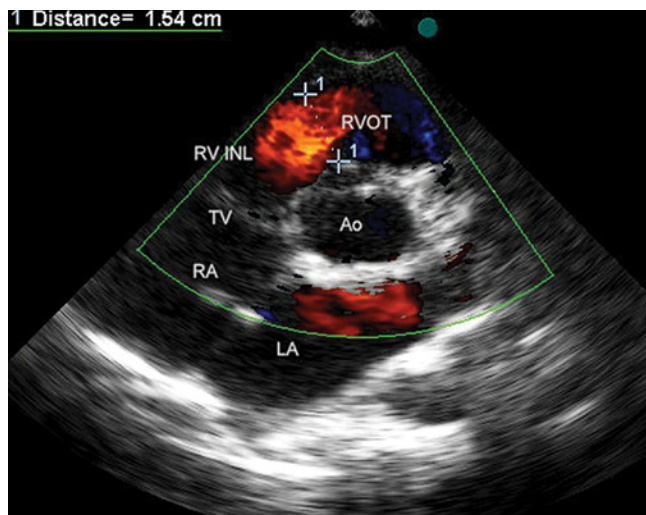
Color Doppler of the flow through the RVOT ten months after surgery. A view analogous to the one used in Fig. 2. Only mild turbulences of the flow are visible, no residual structures obstructing RVOT are present
